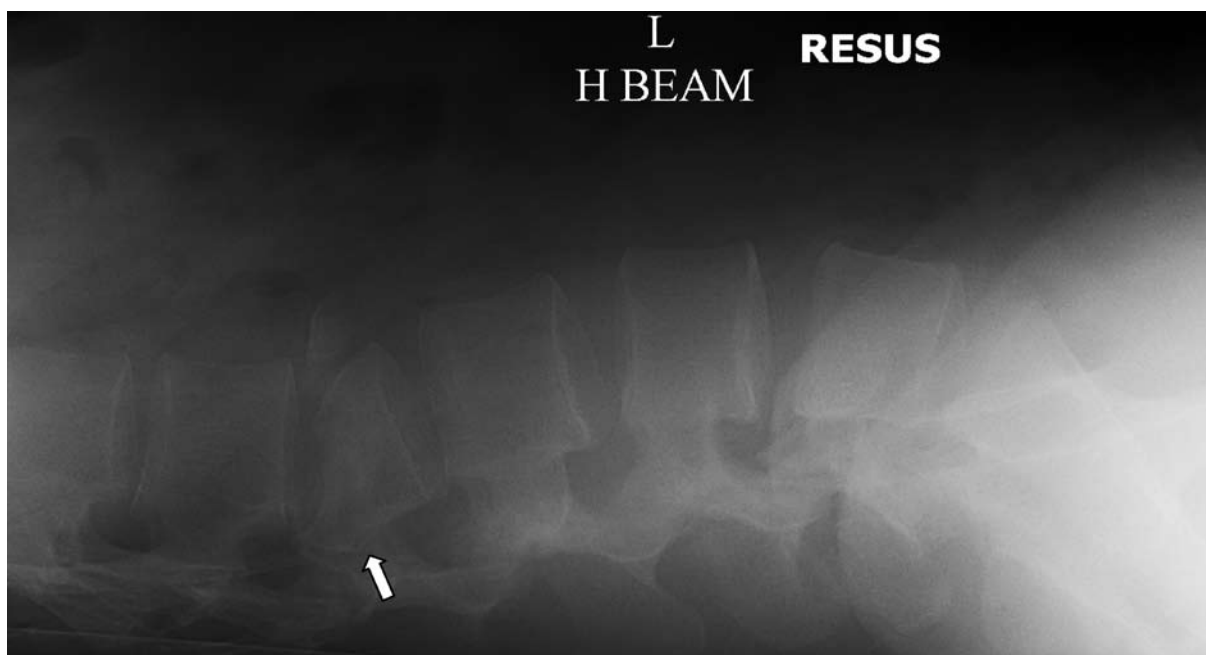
Portable lateral lumbar spine radiograph demonstrating an unstable L2 burst fracture with retropulsion of a fracture fragment into the spinal canal (white arrow).
